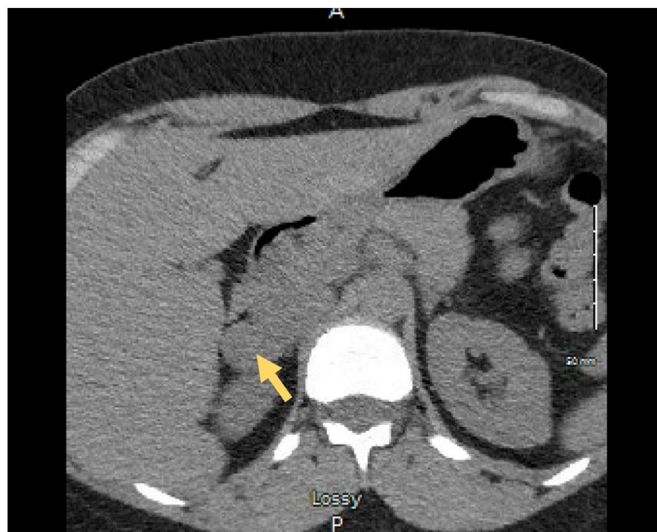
Adrenal washout computed tomographic scan before administration of contrast medium, showing a right adrenal mass.
